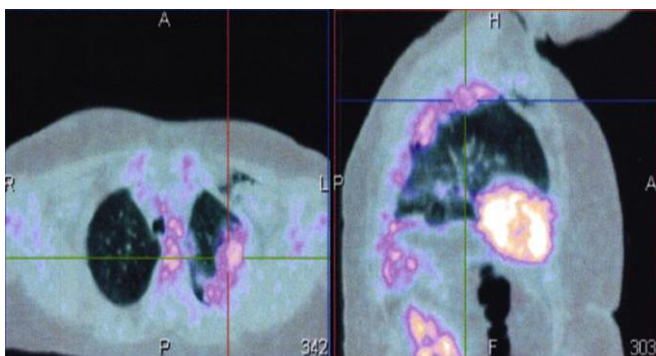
Positron emission tomography with 18F-FDG identified a low metabolic signal on the left pleura.
